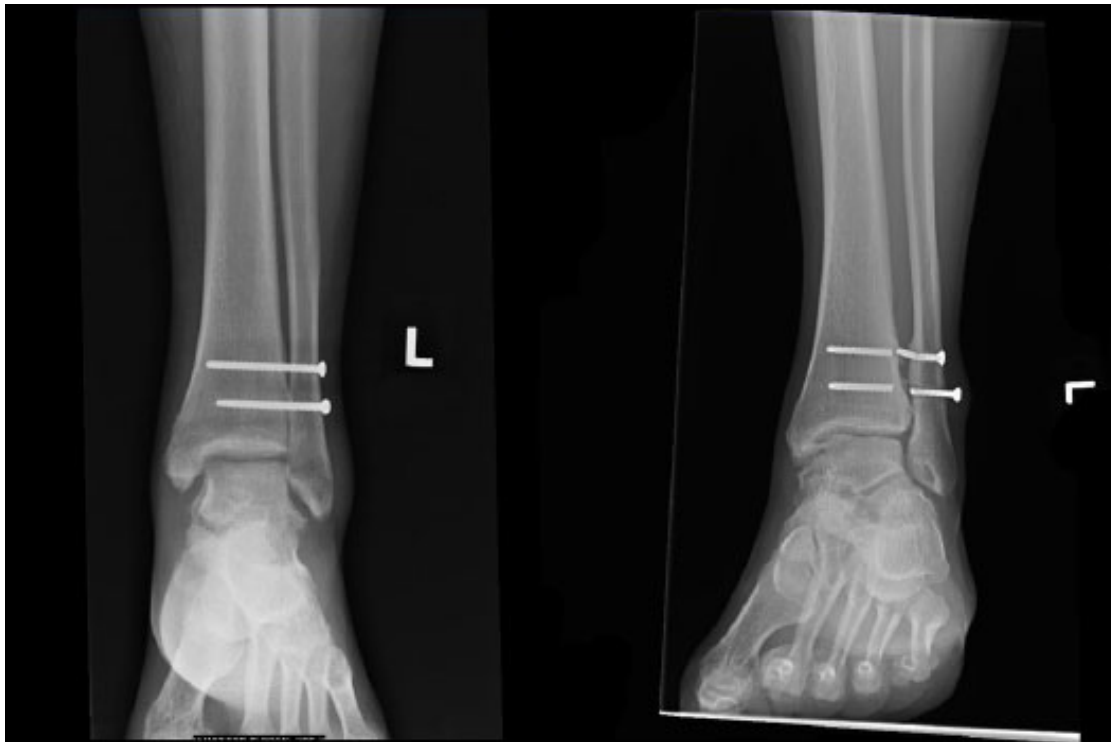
Left: Postoperative follow-up of a patient with a Maisonneuve injury treated with 2 tricortical syndesmotic screws. Right: Radiograph at 2 years postoperation with broken screws. The patient ultimately required screw removal of the lateral screw fragments because of prominence of the distal screw.
